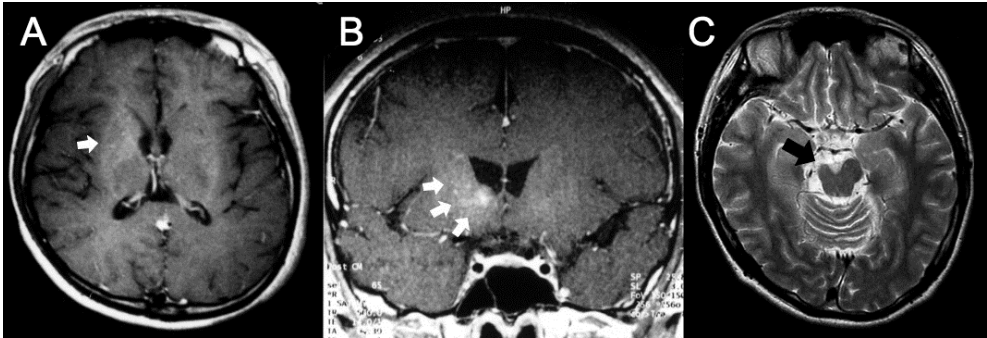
Germinoma in the basal ganglia of a 21-year-old man. A gadolinium-enhanced MR image at initial presentation was diagnosed as normal, although the patient presented with slight left hemiparesis (A). Eight months later, enhanced MRI demonstrated slight enhancement (B), and biopsy confirmed the diagnosis of germinoma (B). The tumor was well controlled after chemo-radiotherapy, but the patient remained hemiparetic. Hemiatrophy of the cerebral peduncle was evident after 12 years (C).
